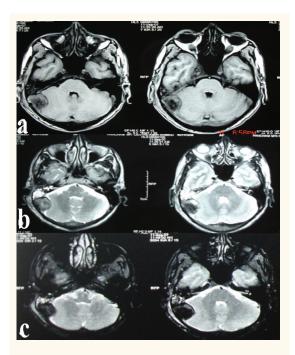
A: Axial T1-weighted magnetic resonance image showing hypointense signal with peripheral hyperintensity and right mastoid showing hypointense signal; B: Axial T2-weighted image showing hypointense signal with peripheral hyperintensity and right mastoid showing hyperintense signal; C: Gradientecho sequence showing hypointense signal.
